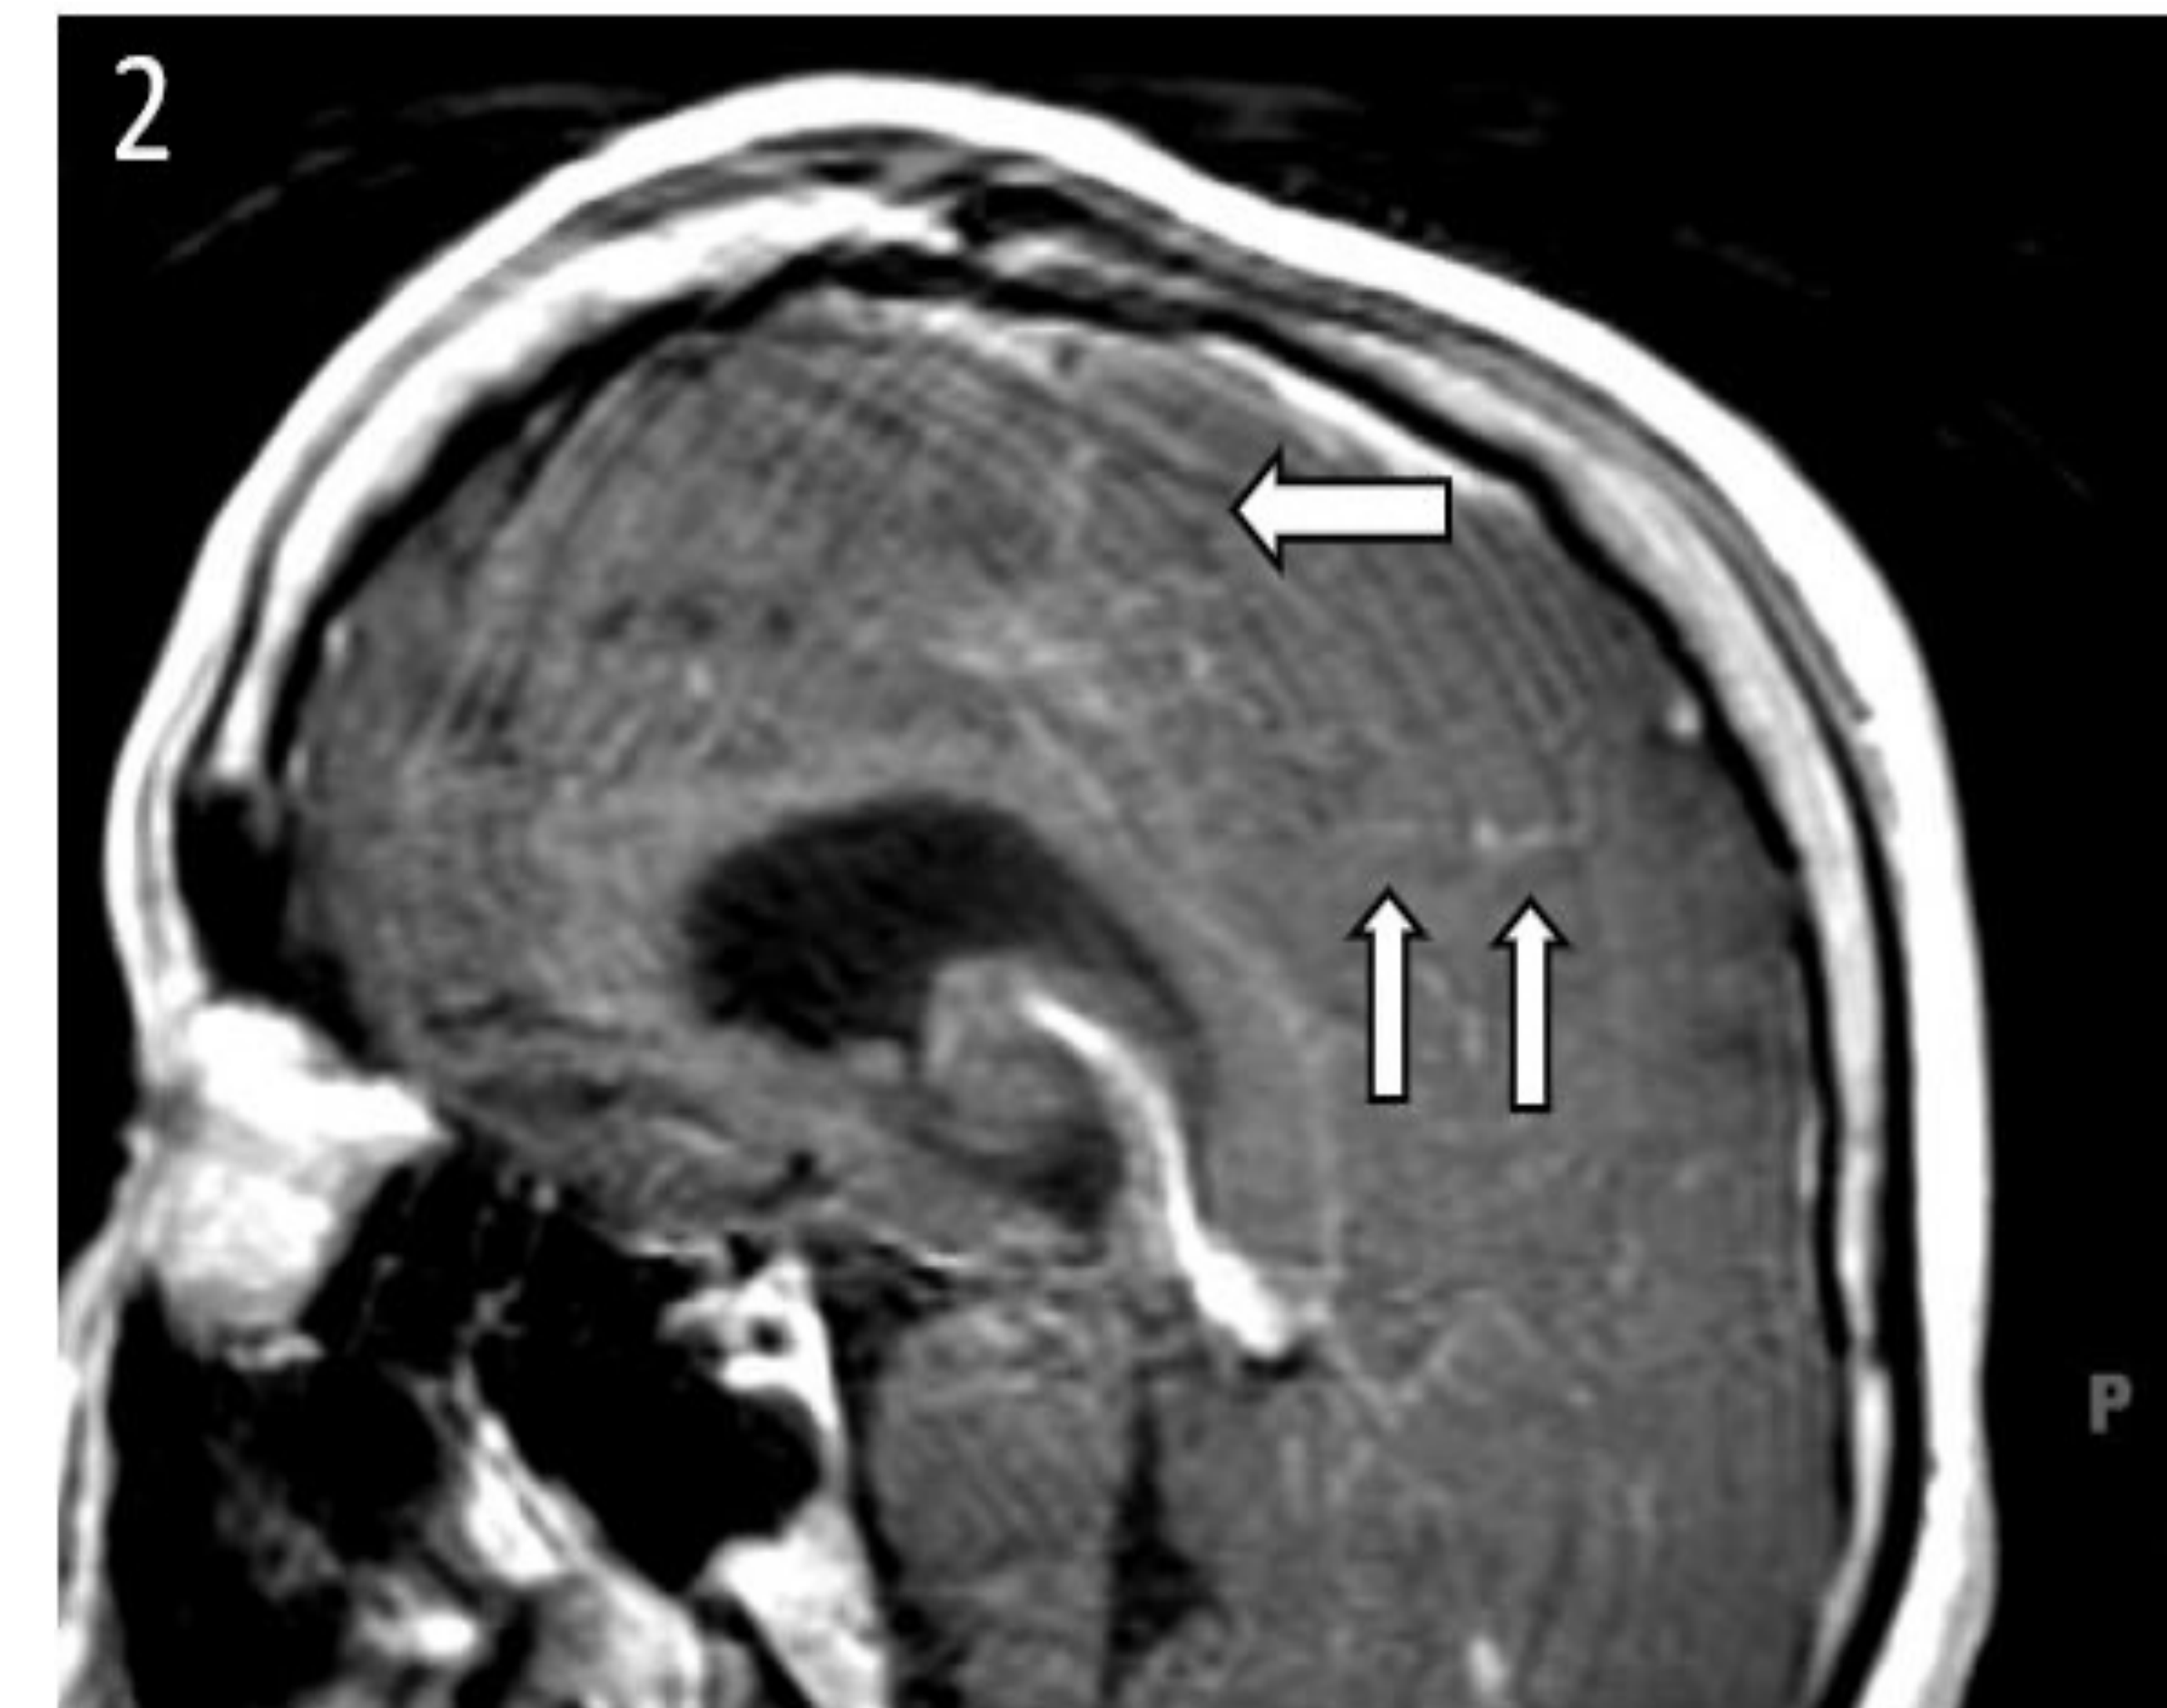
Sagittal MRI View Demonstrating Nodular Leptomeningeal Enhancement of the Left Cerebral Hemisphere
